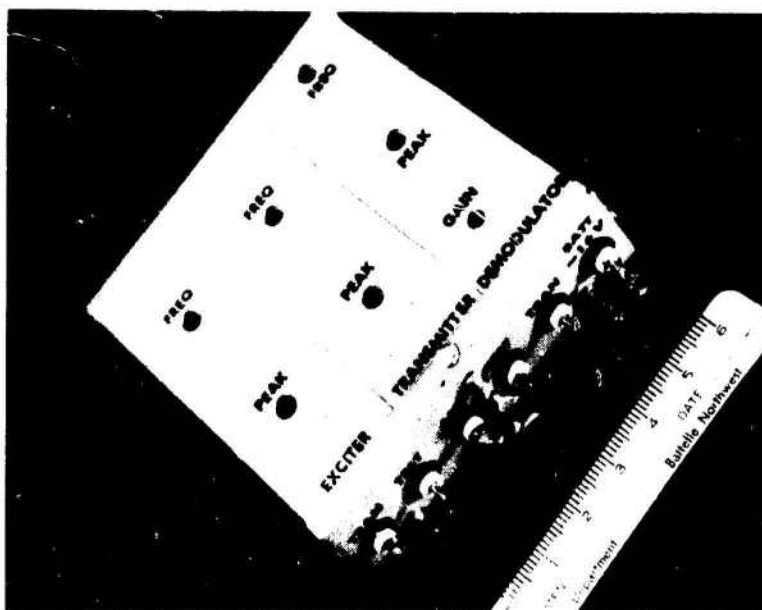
Doppler flowmeter telemetry unit, Pierson Laboratories type (purchased 1971). Case does not hold batteries.
